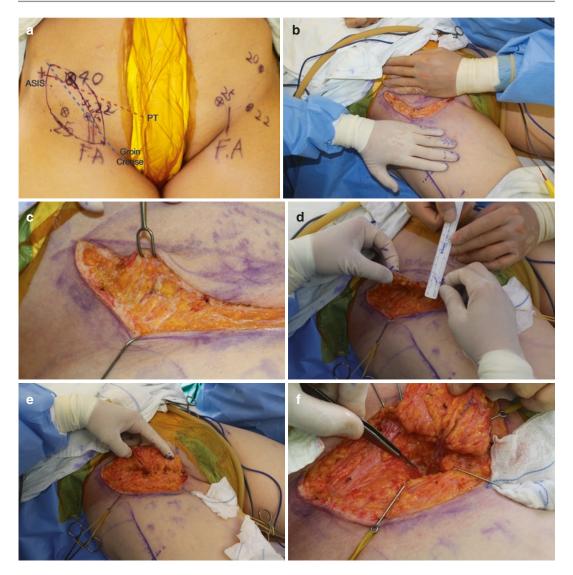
The sequence of the elevation of the SCIP flap is shown. The SCIP flap design should be made along the axis between the groin crease and the ASIS (anterior superior iliac spine) where the SCIA usually travels. Using the handheld Doppler, the medial and lateral perforators can be identified and marked (a). The elevation begins from the lateral inferior margin with traction as the superficial fascia will be most evident (b). Once the superficial fascia
